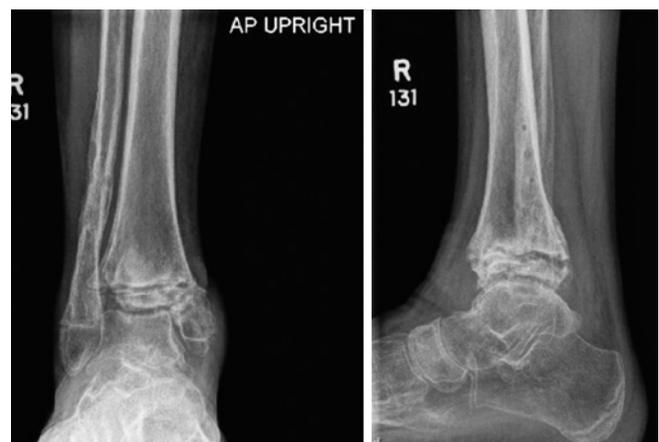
Preoperative anteroposterior and lateral right ankle radiographs demonstrating severe end-stage post-infectious arthritis.
